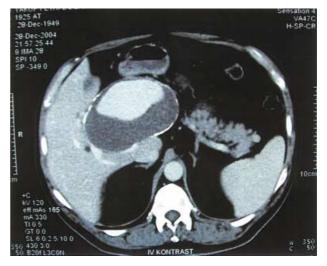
CT angiography showing contrast in the lumen of the aneurysm with mural thrombus.
